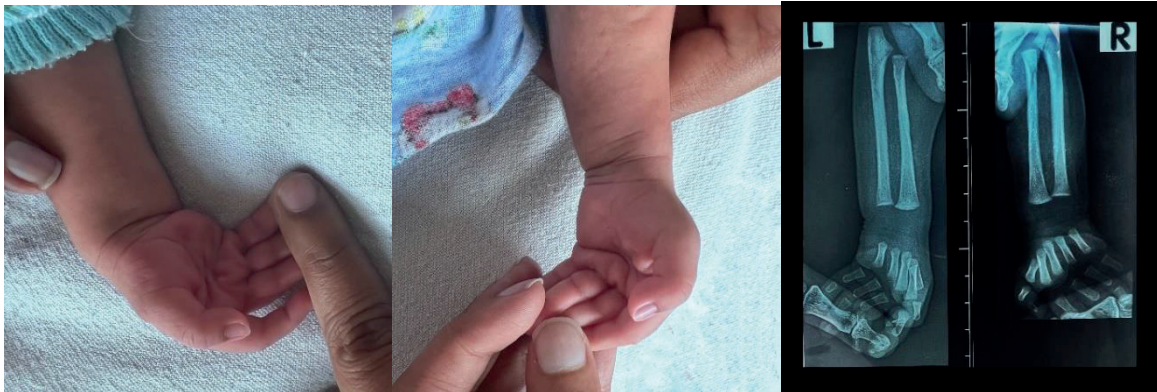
Appearance of the hand of the baby and Radiographic findings
